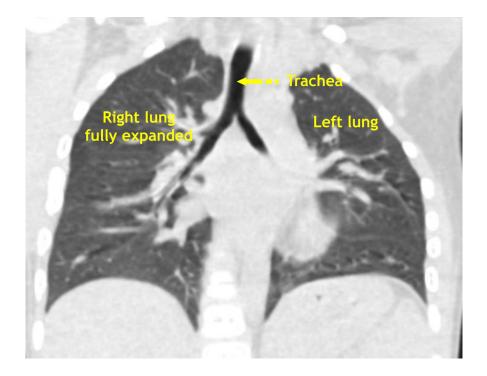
Post-operative Coronal CT Image show normal lung parenchyma (Image Credits: Dr. Viral B. Patel)
